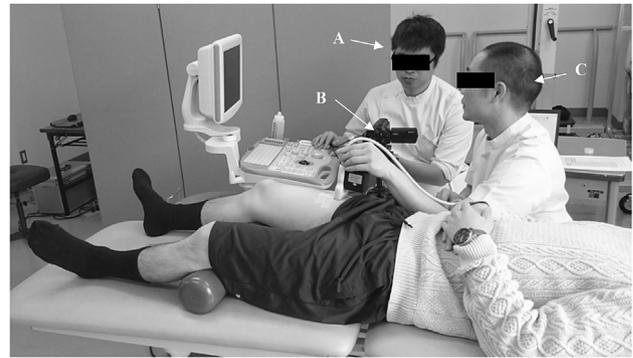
Measurements of the transducer tilt and ultrasound.
